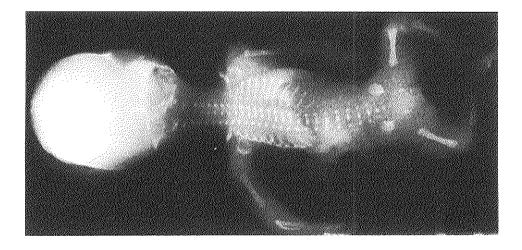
Post mortem radiograph of fetus 6. There are short ribs and short appendicular bones. Note the aspect of the tibiae.
